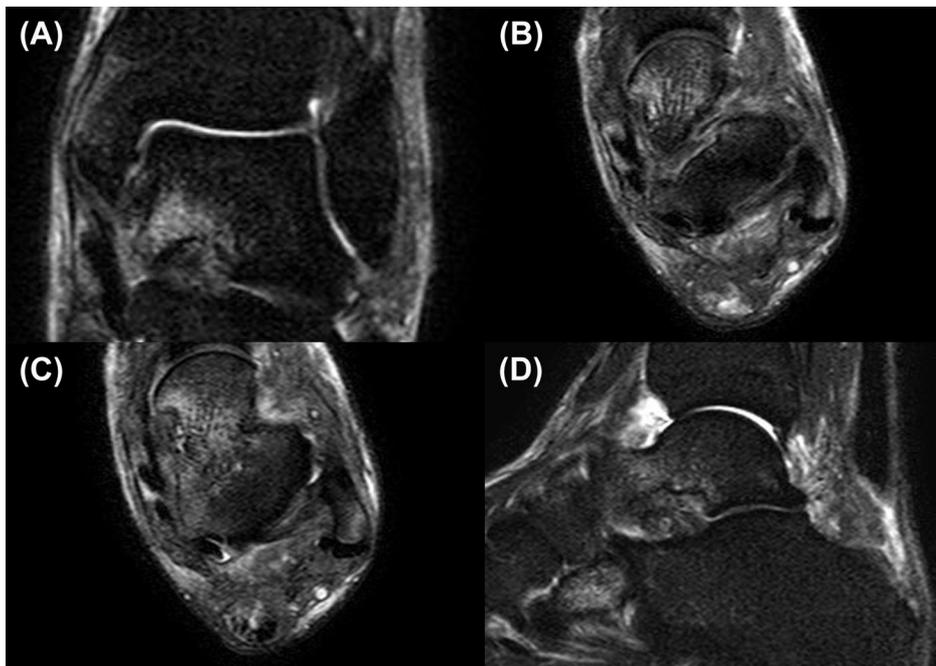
(A–D) Magnetic resonance imaging showing that the anterior talofibular and deltoid ligaments were torn with marrow oedema in the medial talus and medial malleolus. There was no evidence of syndesmotic injury. A recent complete tear of the Achilles tendon at its calcaneal insertion was noted.
